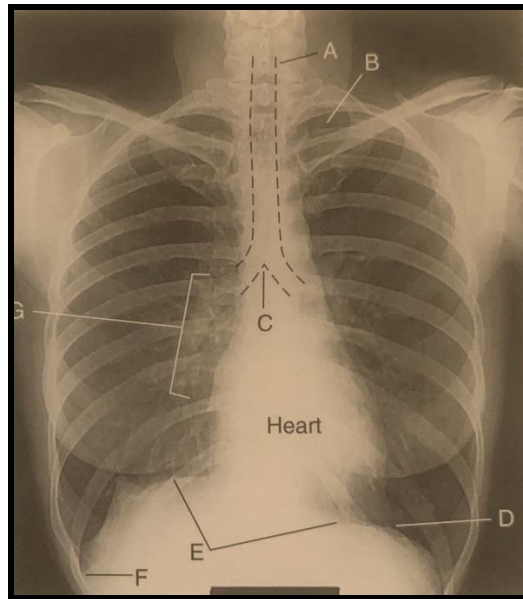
A typical chest x-ray image
